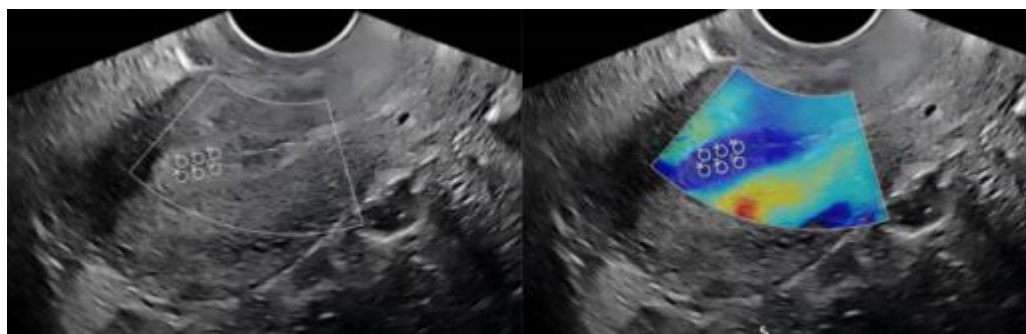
Sonographic image of endometrial elastography measurement. In a standard sagittal section of the uterus, the middle and upper segment of the endometrium is completely covered by the white sampling frame. The white circles represent the six sampling sites for SWE.
